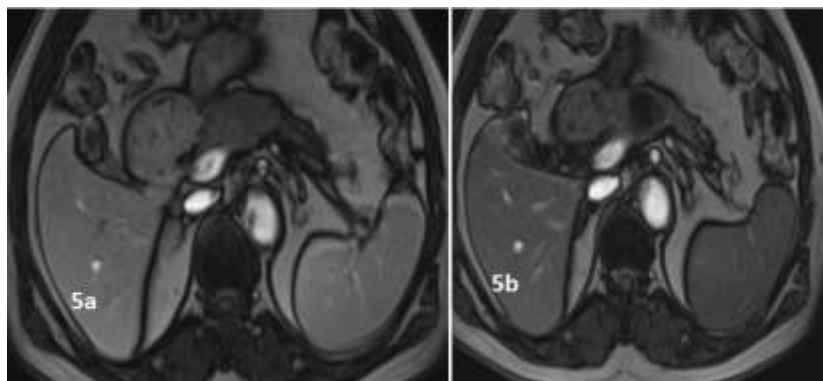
CE MRI of upper abdomen: Axial plane: Pancreas head and neck neoplasm with dilatation ductus pancreaticus and atrophy body and tail.
